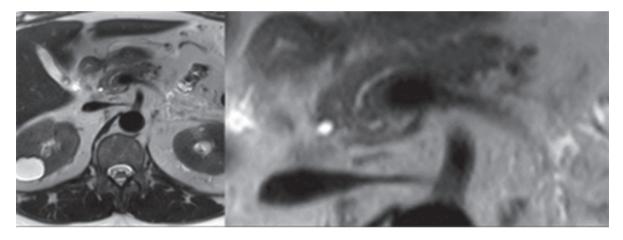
MRI. Partial dorsal agenesis of the pancreas.
